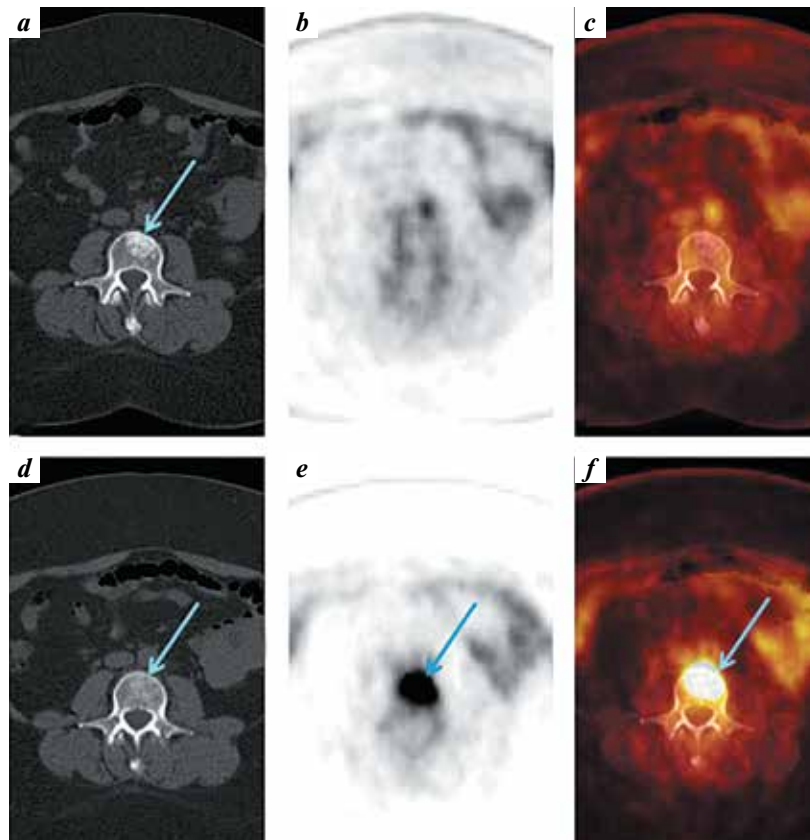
Results of patient examination: computed tomography (CT) scan (a, d); ^{18}F -fluorodeoxyglucose positron emission tomography (PET) scan (b, e); PET/CT scan (c, f). Axial view. Metastasis in the L3 vertebra (blue arrows) before (d, e, f) and after (a) treatment. The pretreatment scans demonstrate a mixed focus of radiopharmaceutical accumulation in the body of the lumbar vertebra; the posttreatment scans demonstrate significantly increased density of the metastatic tumor with no radiopharmaceutical accumulation (below the accumulation of ^{18}F -fluorodeoxyglucose in intact bone tissue)
